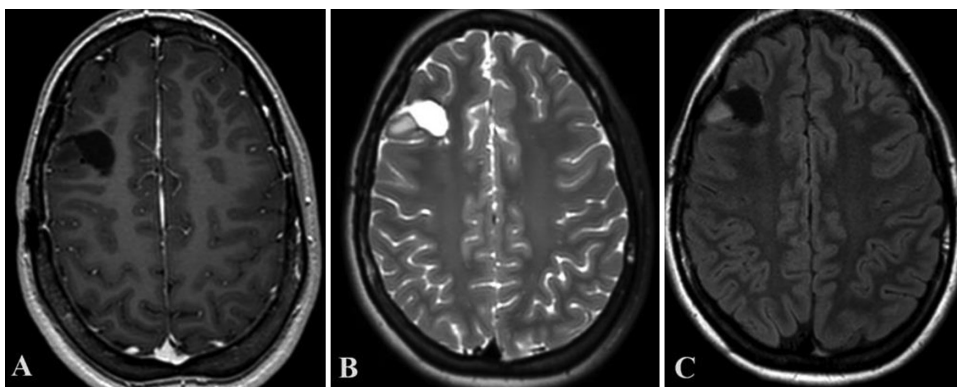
Delayed postoperative axial contrast-enhanced T1-weighted (A), T2-weighted (B), and FLAIR (C) MR images demonstrating local recurrence.
